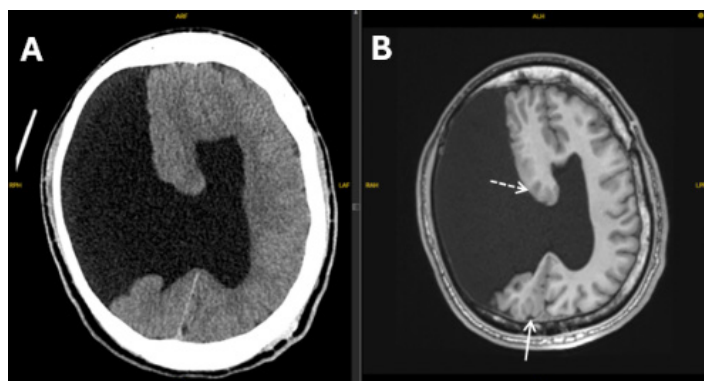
(A) Large right frontoparietal open-lip schizencephaly demonstrated on non-contrast computed tomography. (B) T1-weighted non-contrast magnetic resonance imaging demonstrates heterotopic gray matter (dashed arrow) and polymicrogyria (solid arrow).
